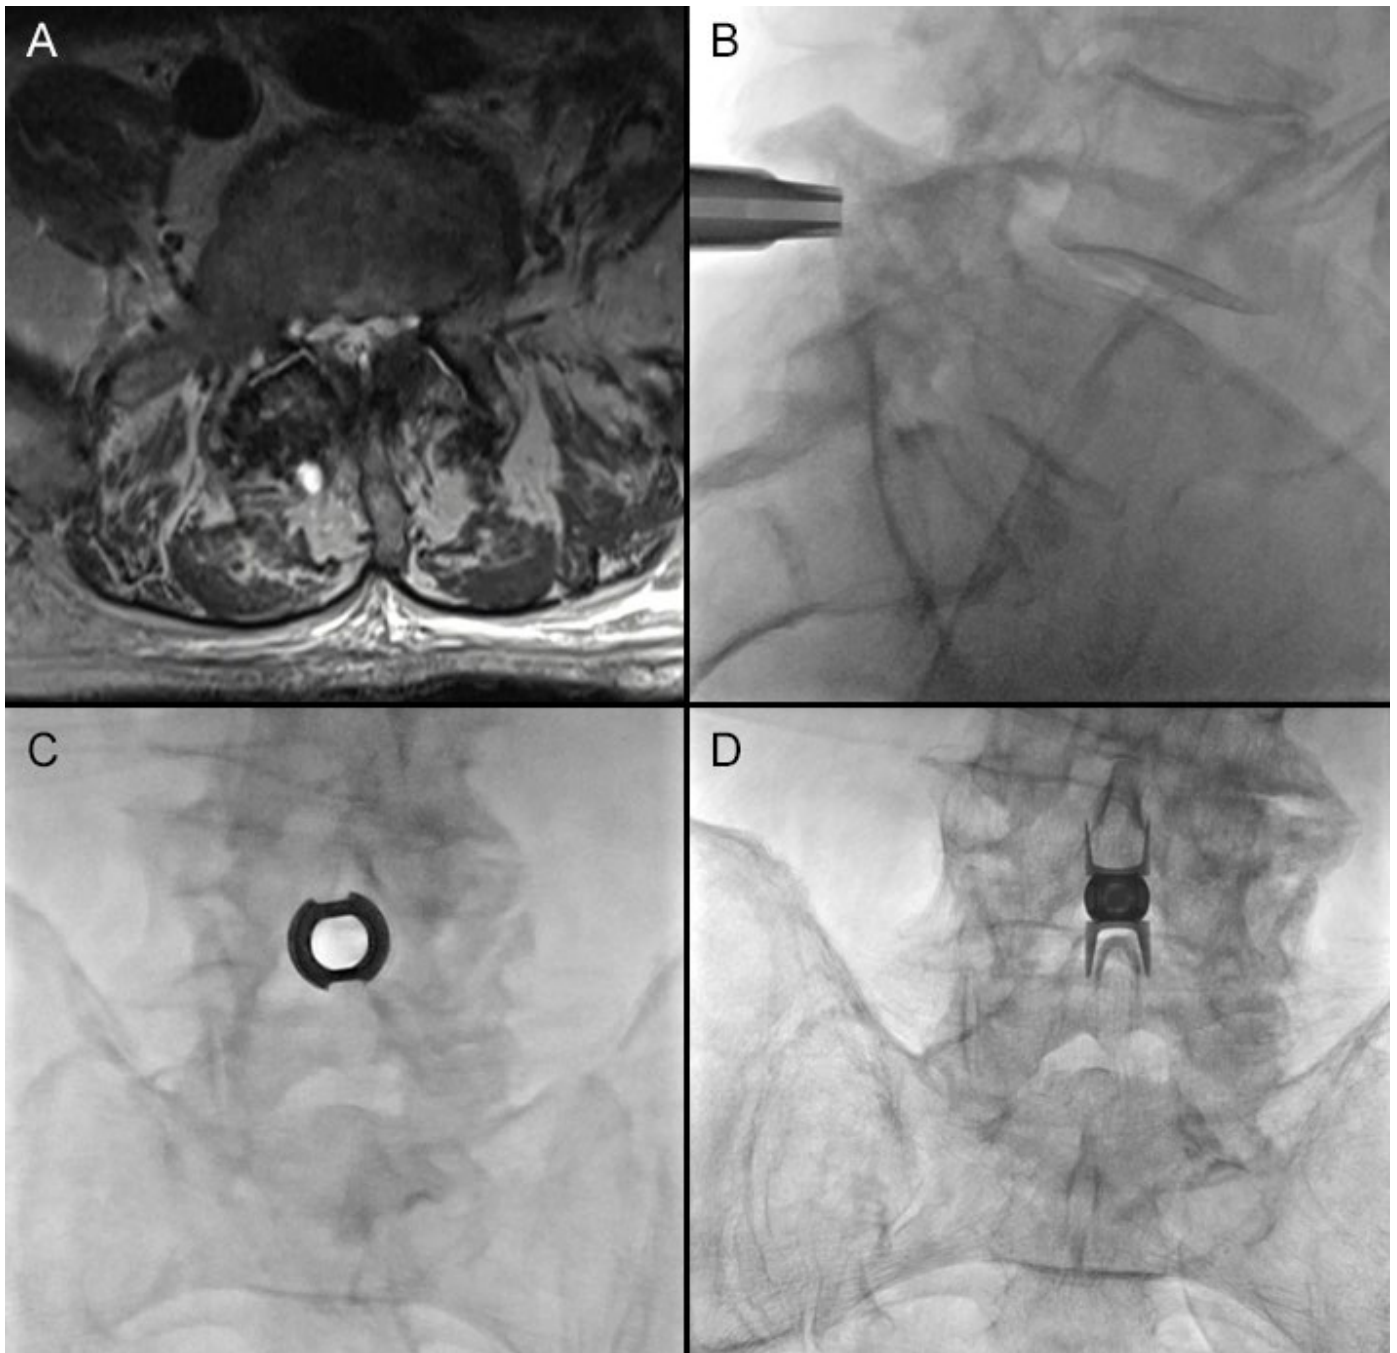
An elderly patient presented with neurogenic claudication. (A) Axial T2 weighted MRI demonstrates severe canal stenosis. (B) and (C) Intraoperative pictures demonstrate the dilator being placed percutaneously between the spinous processes followed by an AP view of the working canula. (D) The final picture demonstrates the fully deployed device. The patient was discharged several hours later to home.
